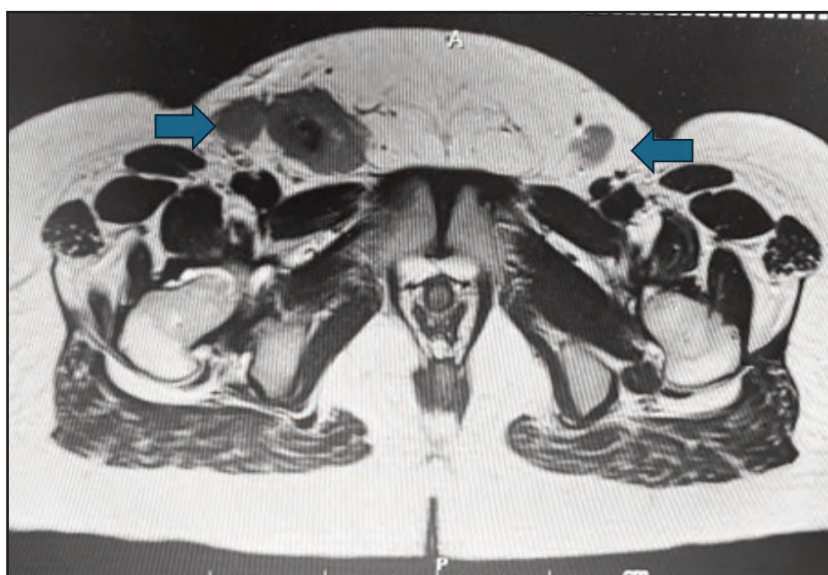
Axial view of MRI pelvis showing bilateral inguinal lymph node metastases
